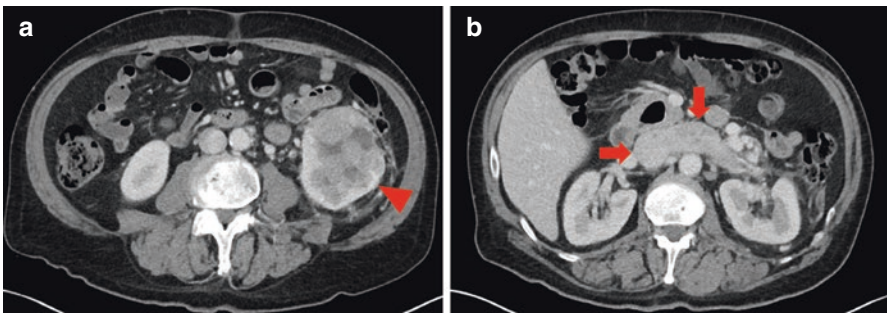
CT images of a clear cell RCC with venous invasion. (a) Axial, venous phase image shows a large heterogeneously enhancing left-sided renal mass (red arrowhead). (b) In a more superior axial, venous phase CT image, the left renal vein and inferior vena cava are enlarged with internal heterogeneous enhancement (red arrows), compatible with venous invasion of the tumor. Following imaging the mass was surgically resected and was found to be clear cell RCC
